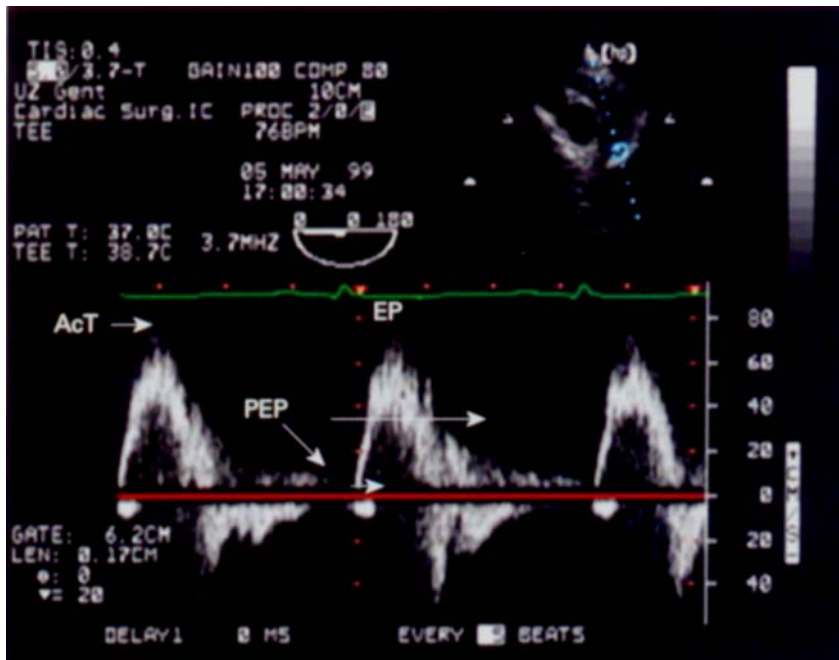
Pulmonary artery flow (pulsed wave Doppler) in the main stem of the pulmonary artery. AcT = acceleration time, EP = ejection period, PEP = pre-ejection period.
